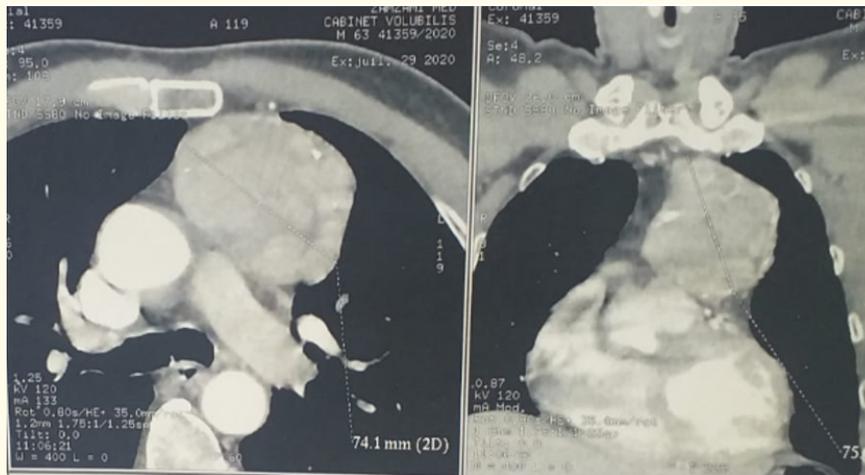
Thoracic CT scan showing a resectable anterior mediastinal mass in favor of thymoma.
